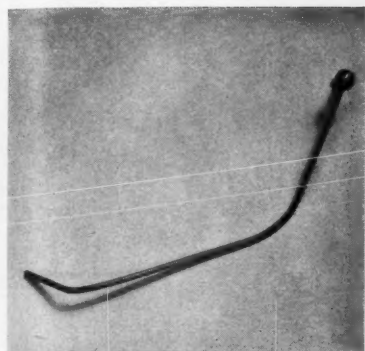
(Left) Photograph of the prosthetic device bent to shape for implantation. (Right) Postoperative roentgenogram showing the prosthesis in place.
